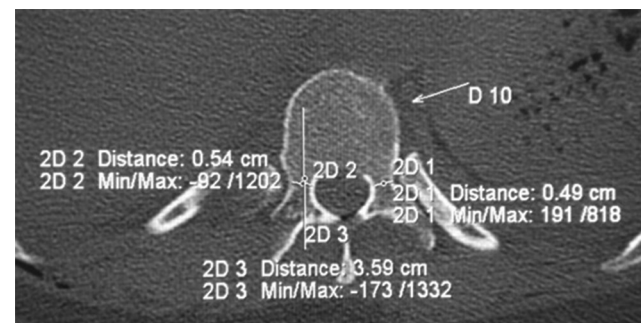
Preoperative calculation using computed tomography (CT) image.
